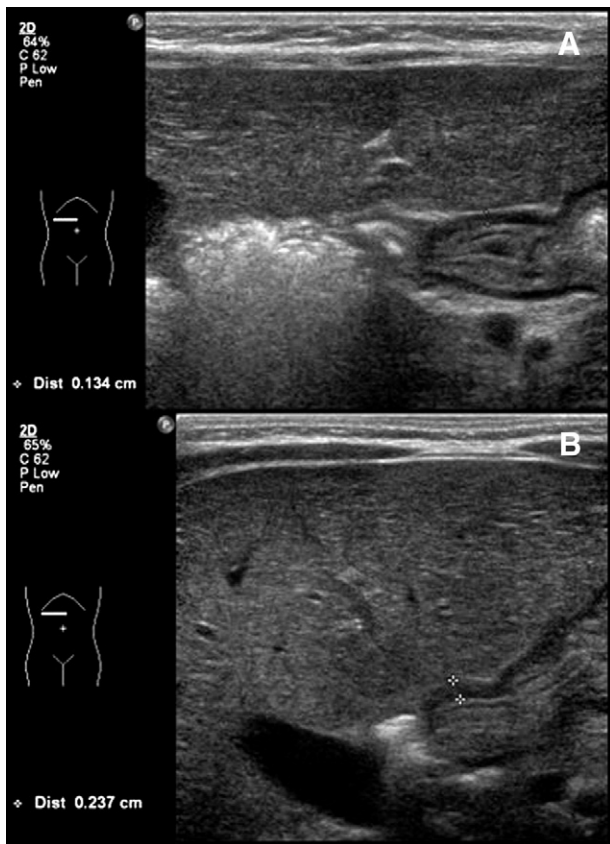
Representative ultrasound images depicting the pylorus in relaxation (A) and the contracted pylorus (B).
